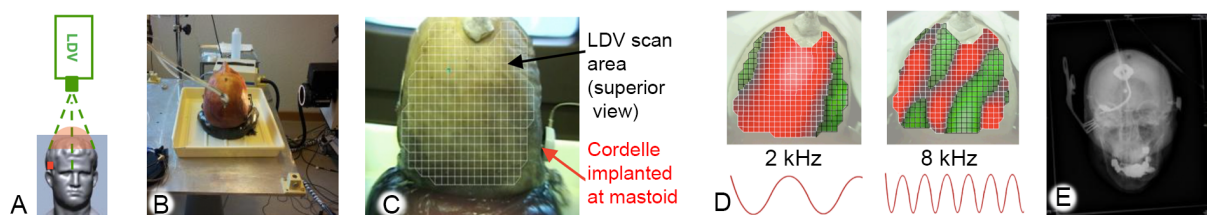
Wave propagation in the skull bone during bone conduction stimulation: Measurement setup included a BAHA (= Cordelle) (A,C) that was directly driven with sine signals. The motion of the skull was measured using a Laser Doppler vibrometer (A, C). A Hydrophone was placed lateral (B, E). (D) Example of a motion pattern of a skull (superior view) at 2 kHz (left) and 8 kHz (right).
